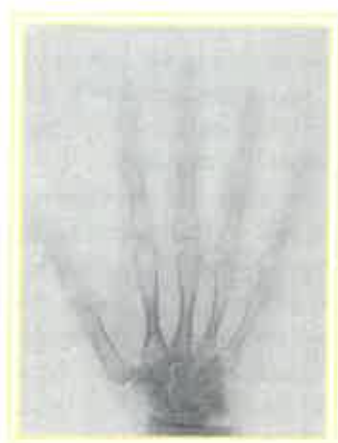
X-ray of hand, with permission of Rosa Lacerda, the owner.
